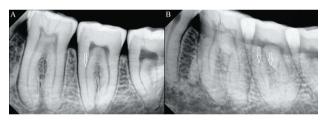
Picture of lower molars in two radiographic techniques: a – paralleling technique (pt), b – same lingual opposite buccal technique (slob).
